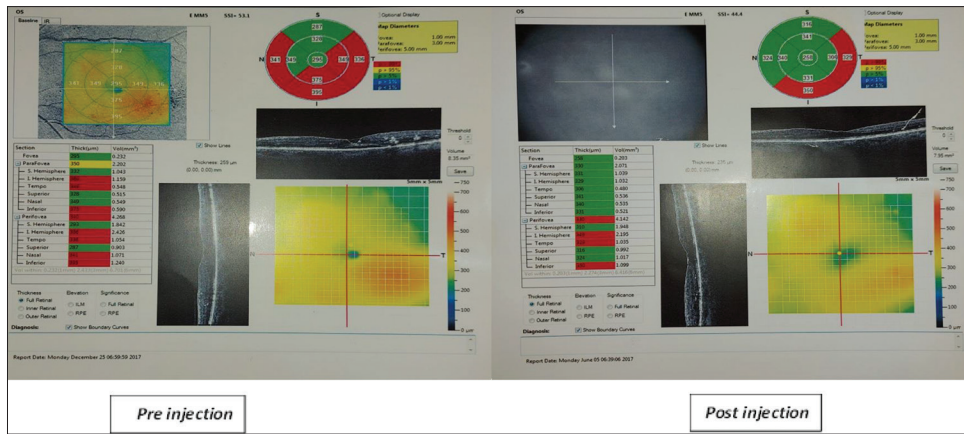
CT of preinjection and postinjection case no. 2. OCT, optical coherence tomography.
